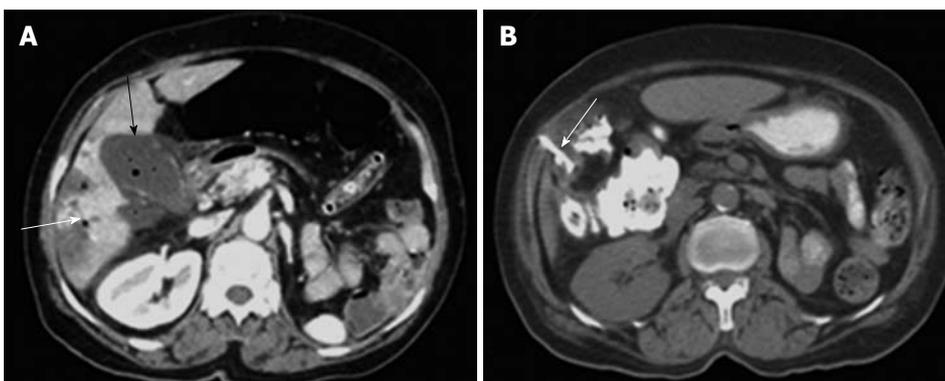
A case of emphysematous cholecystitis. A: Post contrast computed tomography (CT) scan shows thick-enhancing walled gallbladder with turbid fluid content and air loculi seen within its lumen (black arrow). Minimal free pericholecystic fluid collection. Pneumobilia seen within the intrahepatic biliary radicles (white arrow); B: Follow up CT-guided cholecystostomy with drainage catheter seen within the gallbladder lumen (arrow).
